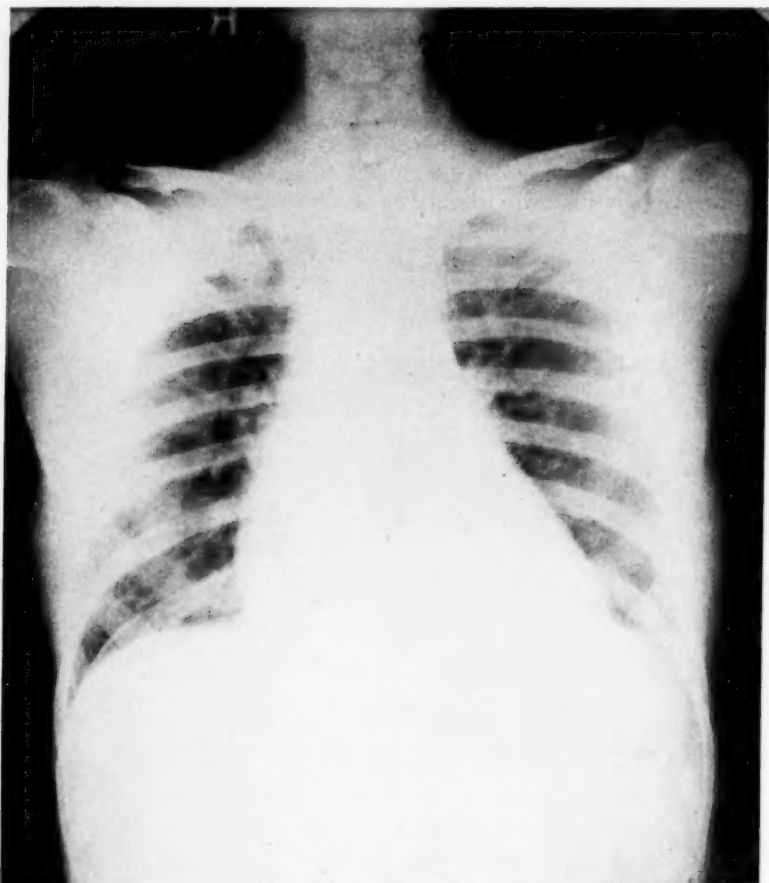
Roentgenogram showing reduction in area of heart shadow by February 3, 1937.
